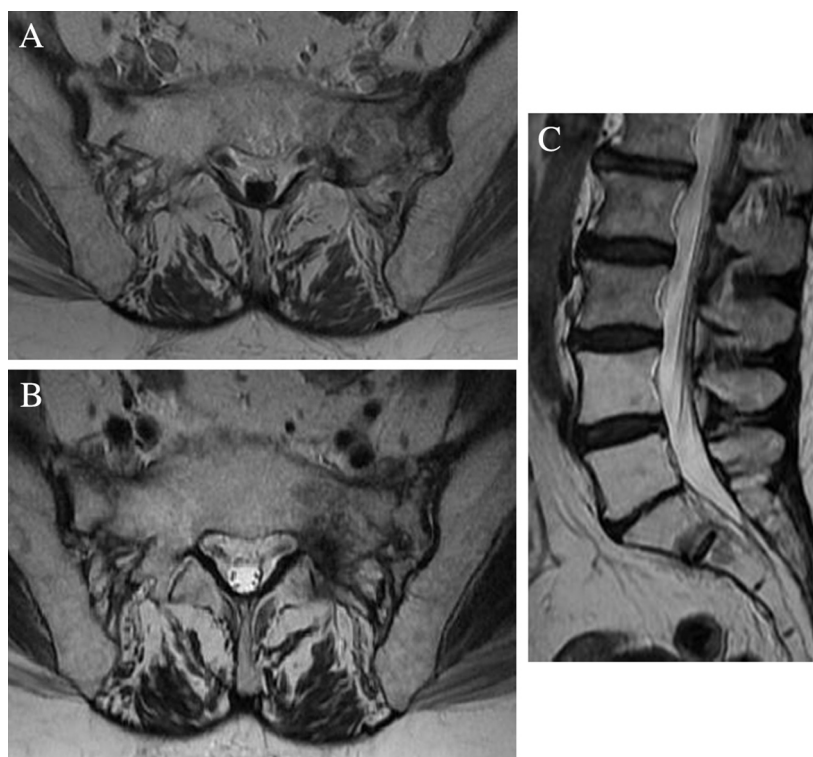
Focally heterogeneous signal is seen on magnetic resonance T1-weighted (A), T2-weighted (B) axial images in the left lateral part of the sacrum. Diffuse signal change in L4-5 and the sacrum on sagittal T2-weighted (C) image due to fatty infiltration of bone marrow after radiotherapy.
